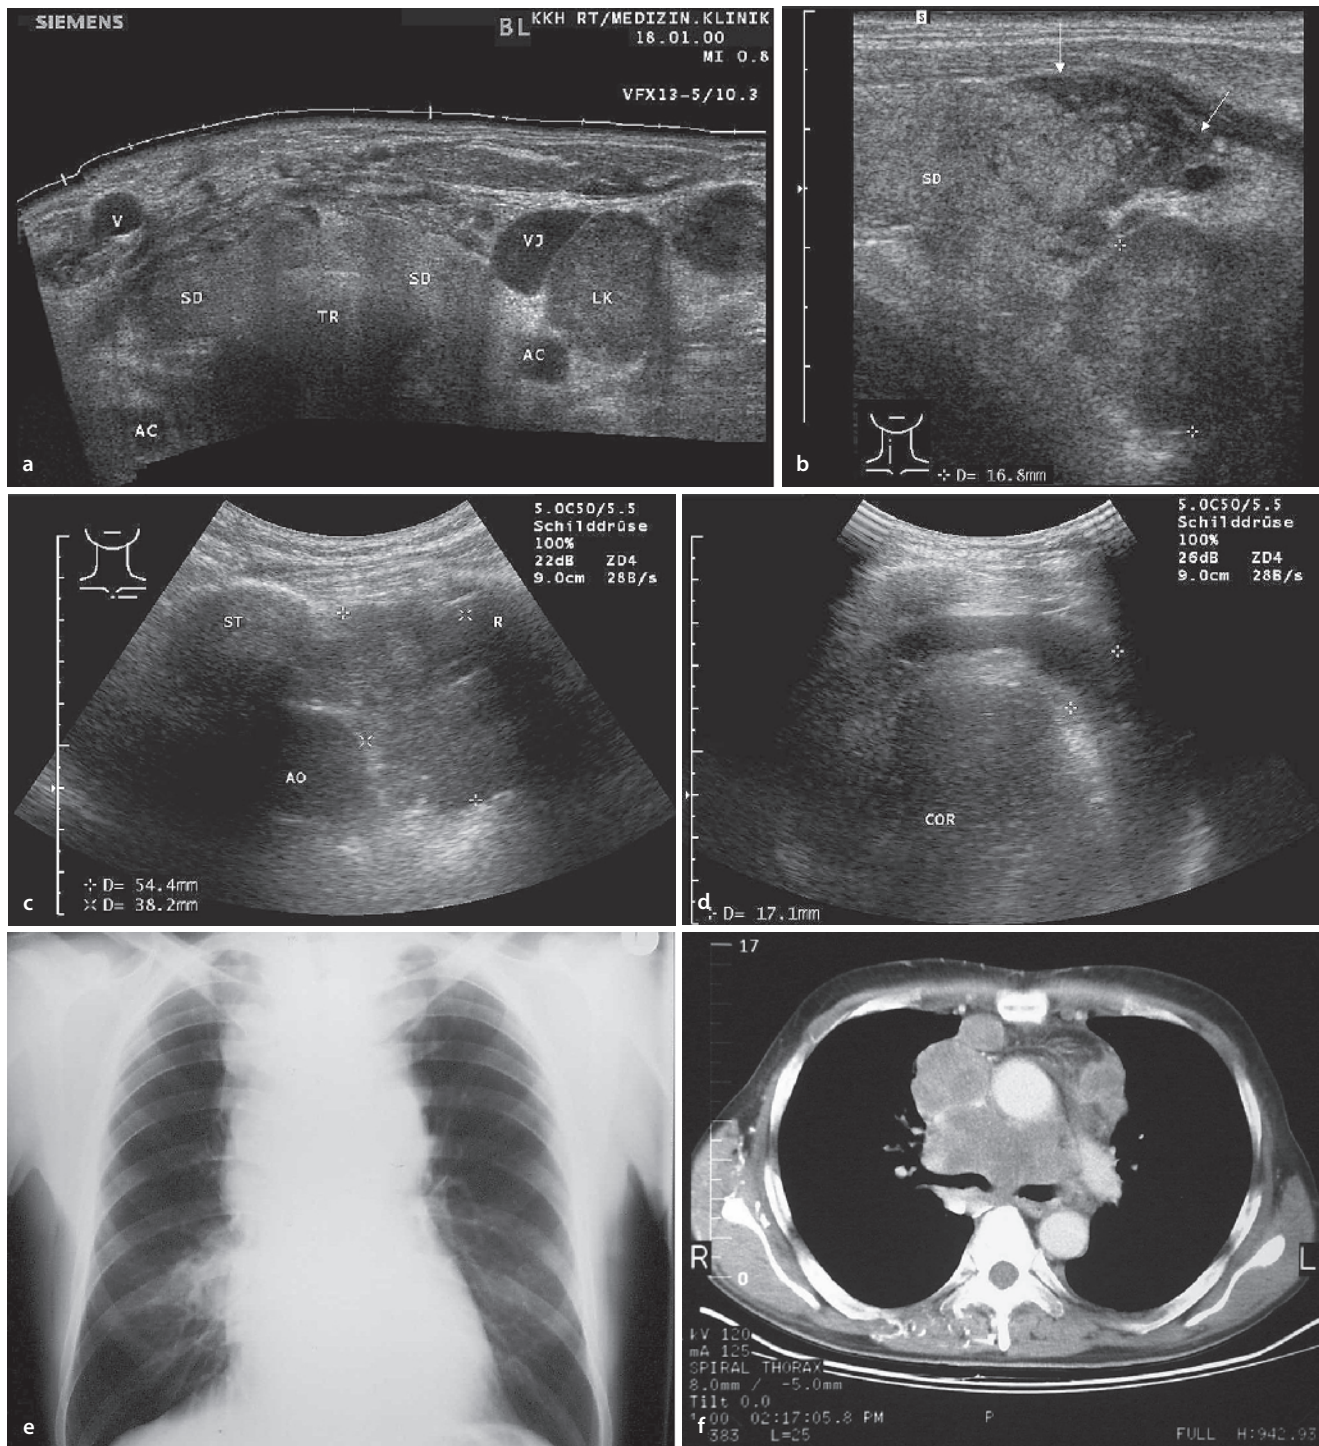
Primary sonographic examination of an upper inflow congestion. a Multiple lymph nodes (*LK*) suspected of malignancy in the neck region. The panorama presentation (SieScape, from Siemens) enables an impressive documentation of a relatively large region of the body. b Low-echo tumor infiltration into the thyroid gland. Tumor masses (*crosses*) reaching into the retrosternal region. c Left parasternal section, in the vicinity of the infiltrating low-echo mass (*crosses*). The wall of the aorta (*AO*) can no longer be sharply delineated. *ST* sternum, *R* rib. d Pericardial deposits and pericardial effusion (*crosses*).
